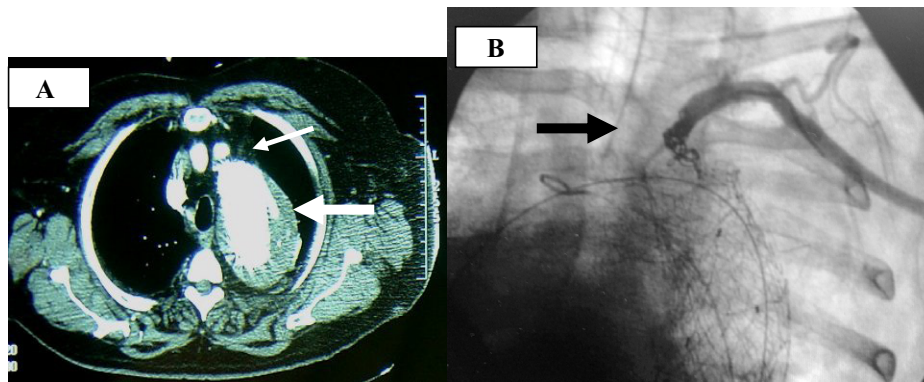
Coil embolization of left subclavian artery. A, Endoleak (large white arrow) on CT-scan originated from left subclavian artery (small arrow) as ultimately demonstrated by angiography. B, Coil embolization of the origin of the subclavian artery (arrow) to correct a type II endoleak.
